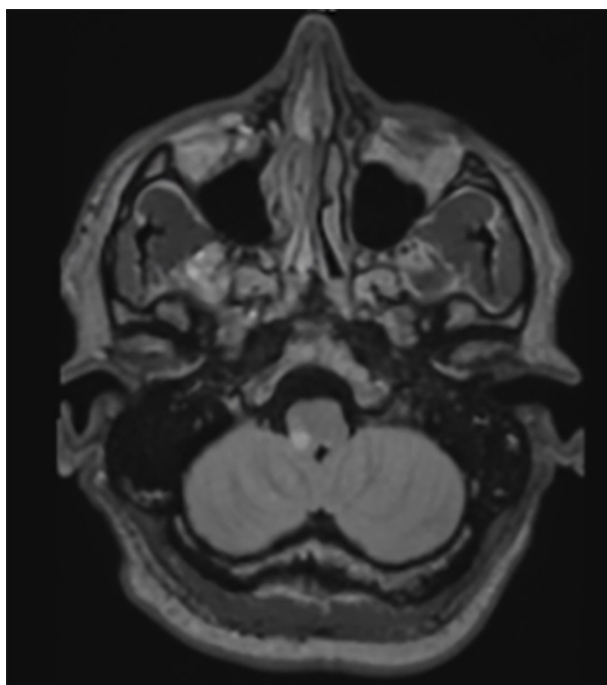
Axial image of MRI brain showing an infarct in the right lateral medulla.
